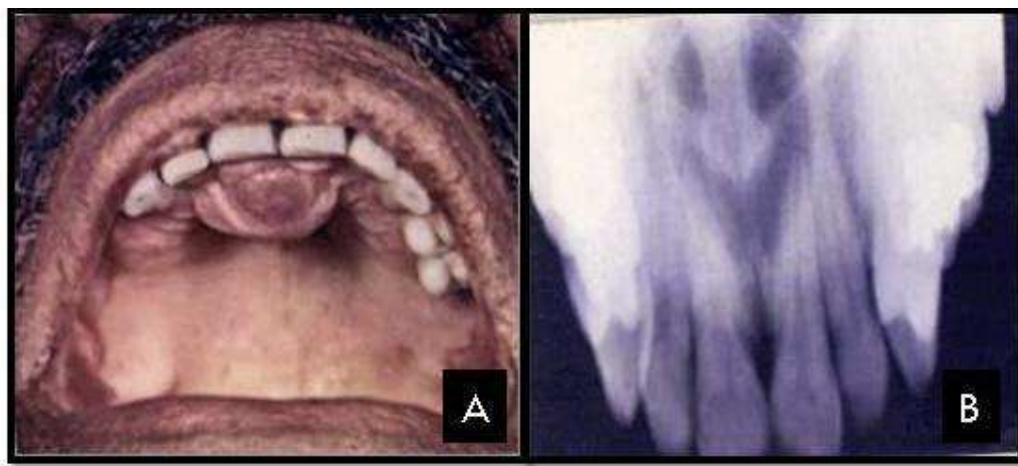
A- Intraoral view. B- Maxillary occlusal radiograph
